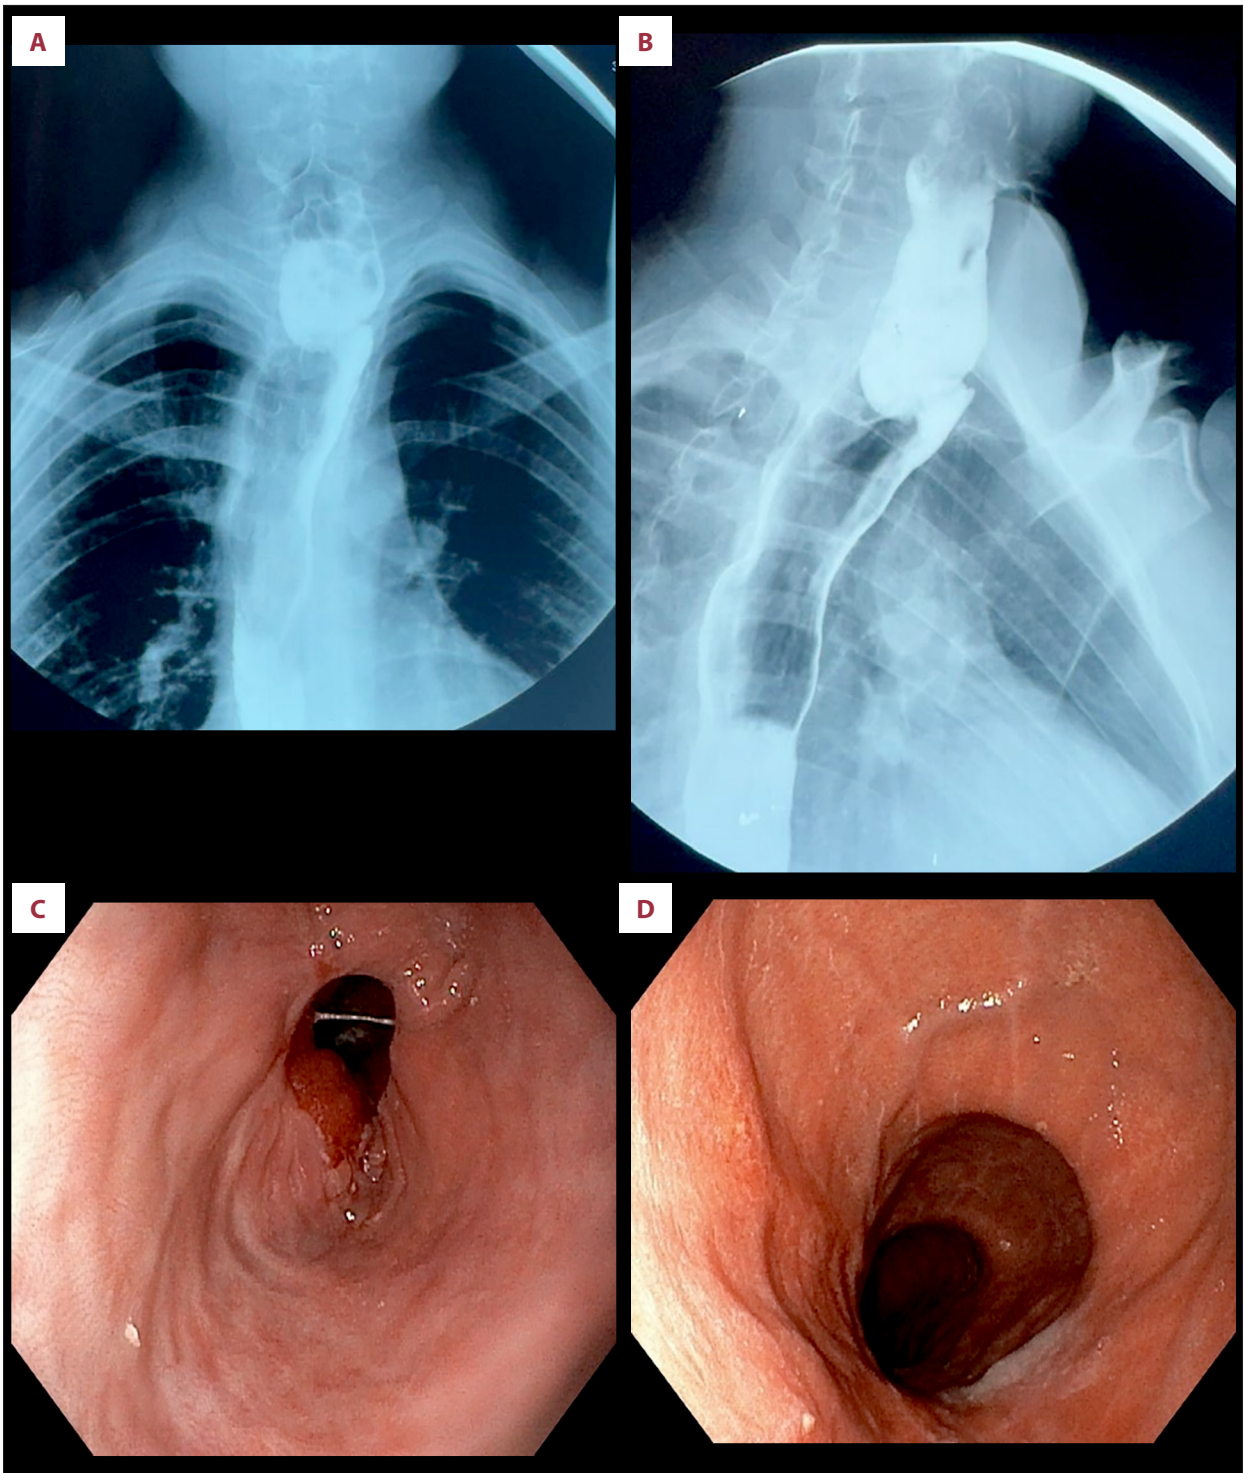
Follow-up contrast esophagography and endoscopic findings at 3 months. (A) Anteroposterior radiograph demonstrating an anastomotic diameter of 20 mm. (B) Lateral radiograph showing satisfactory anastomotic patency. (C) Endoscopic image demonstrating a widely patent esophagogastric anastomosis. (D) Endoscopic image of the gastric conduit.
